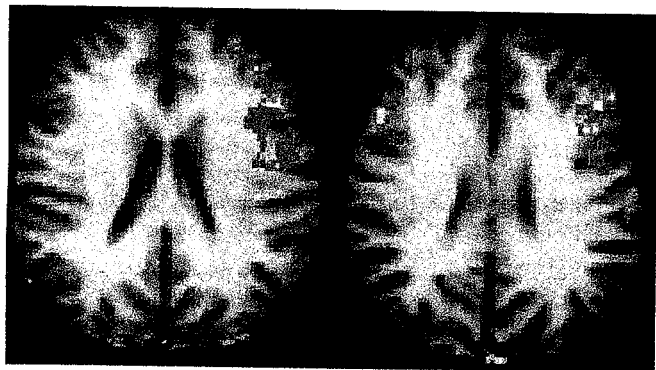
Functional MRI Scans. These scans of human brains show localized average increases in neural activity of males (left) and females (right) while they were judging whether pairs of written words rhymed.
